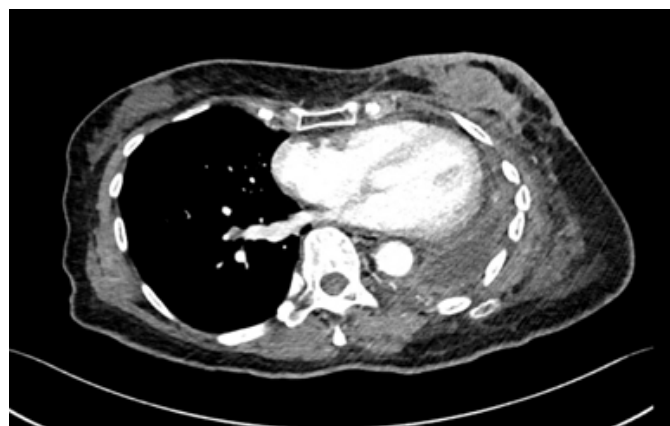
Axial CT scan showing left breast mass with overlying skin thickening. Right breast lesion can also be visualized.
